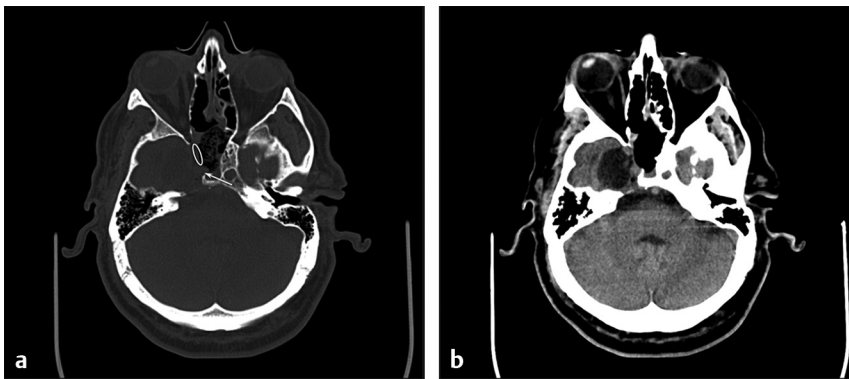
Postoperative CT. (a) Bone window. As planned preoperatively, Mullan's triangle has been opened to communicate the lateral recess of the sphenoid sinus and the middle fossa (*oval*), through which tumor resection was done. Note that the osseous encasement of the internal carotid artery has been removed, preserving the vessel (*arrow*). (b) Soft tissue window. A complete resection, including the posterior fossa component has been achieved.
